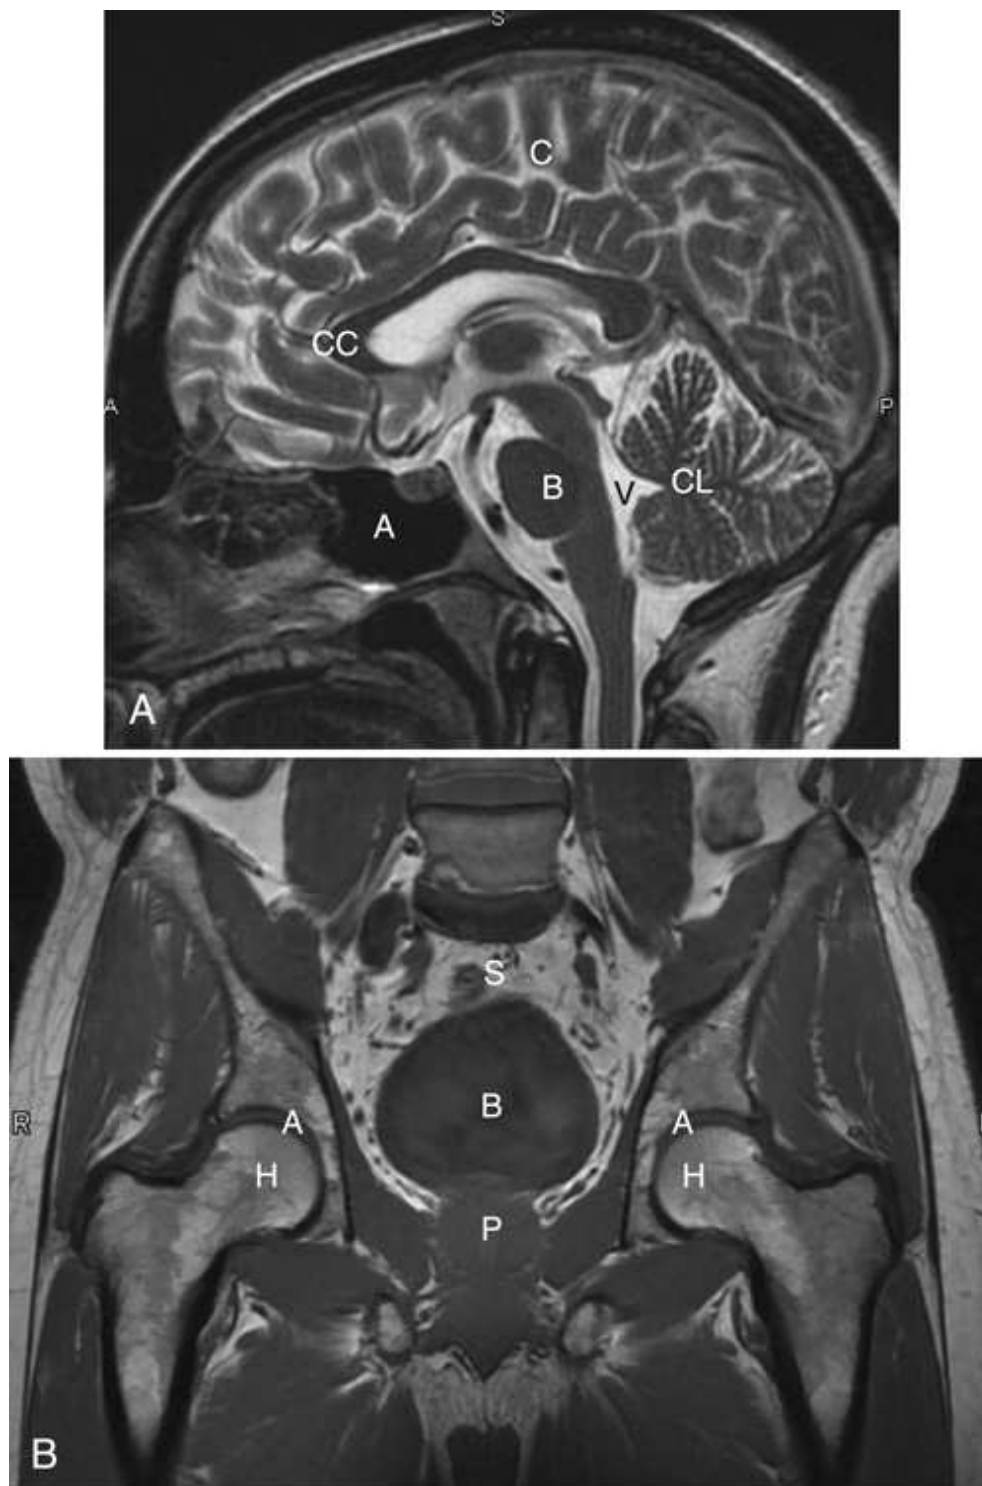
Two images (different patients) from a 3-T superconductive MRI scanner, showing excellent resolution of images. (A) This image shows remarkable anatomic detail in a midsagittal image of the head. *A*, Air in sinuses; *B*, brain stem; *C*, cerebrum; *CC*, corpus callosum; *CL*, cerebellum; *V*, ventricle. (B) This coronal image of the pelvis shows anatomic relationships of the prostate (*P*), which is enlarged and elevating the bladder (*B*). Hips (*H*) and acetabula (*A*) are also shown. A loop of the sigmoid (*S*) colon is on top of the bladder. This degree of resolution in coronal or sagittal images would be difficult to obtain by reformatting a series of transverse CT slices.
